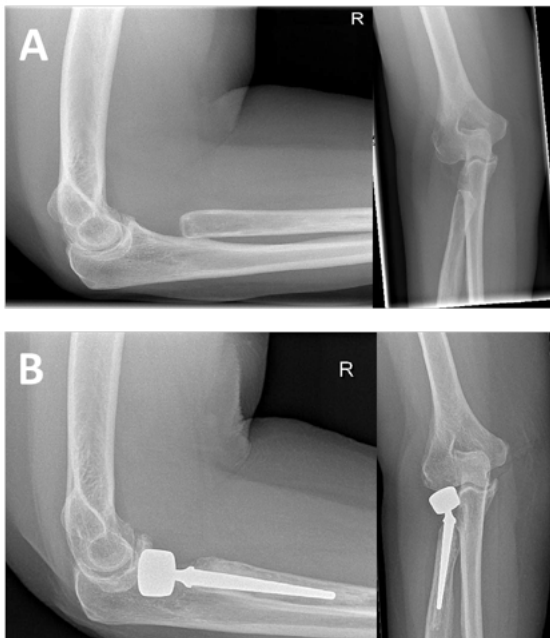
preoperative radiographs of patient with malalignment of the radius following radial head resection [A] and postoperative result after bipolar radial head arthroplasty [B].
